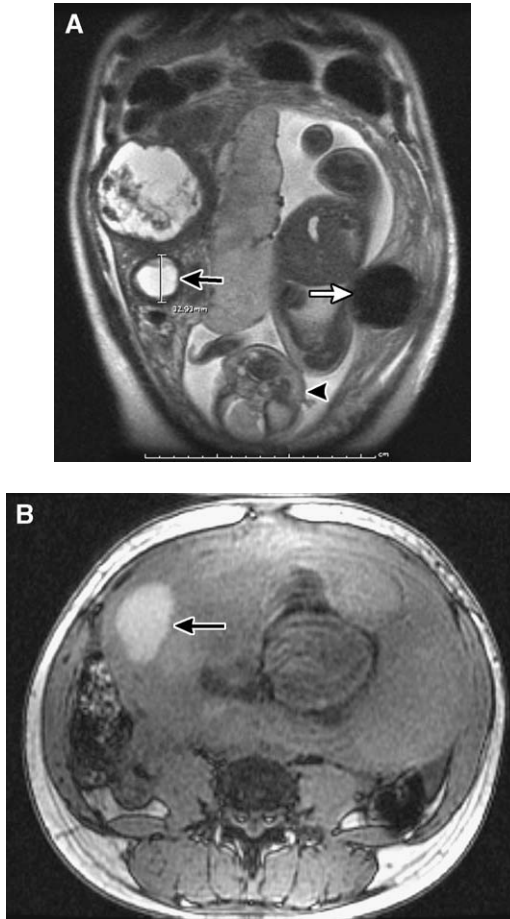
(A) Pregnant woman with acute right flank pain. Coronal T2-weighted scan demonstrates two hyperintense myomas on the right that are degenerated; the more inferior one (*black arrow*) measures approximately 3 cm and exhibits a dark rim. The hypointense myoma (*white arrow*) in the left uterine wall is not degenerated. (B) Axial T1-weighted image shows the smaller myoma is hyperintense (*black arrow*) because of hemorrhage, and therefore, has infarcted acutely and accounted for the patient's pain.
